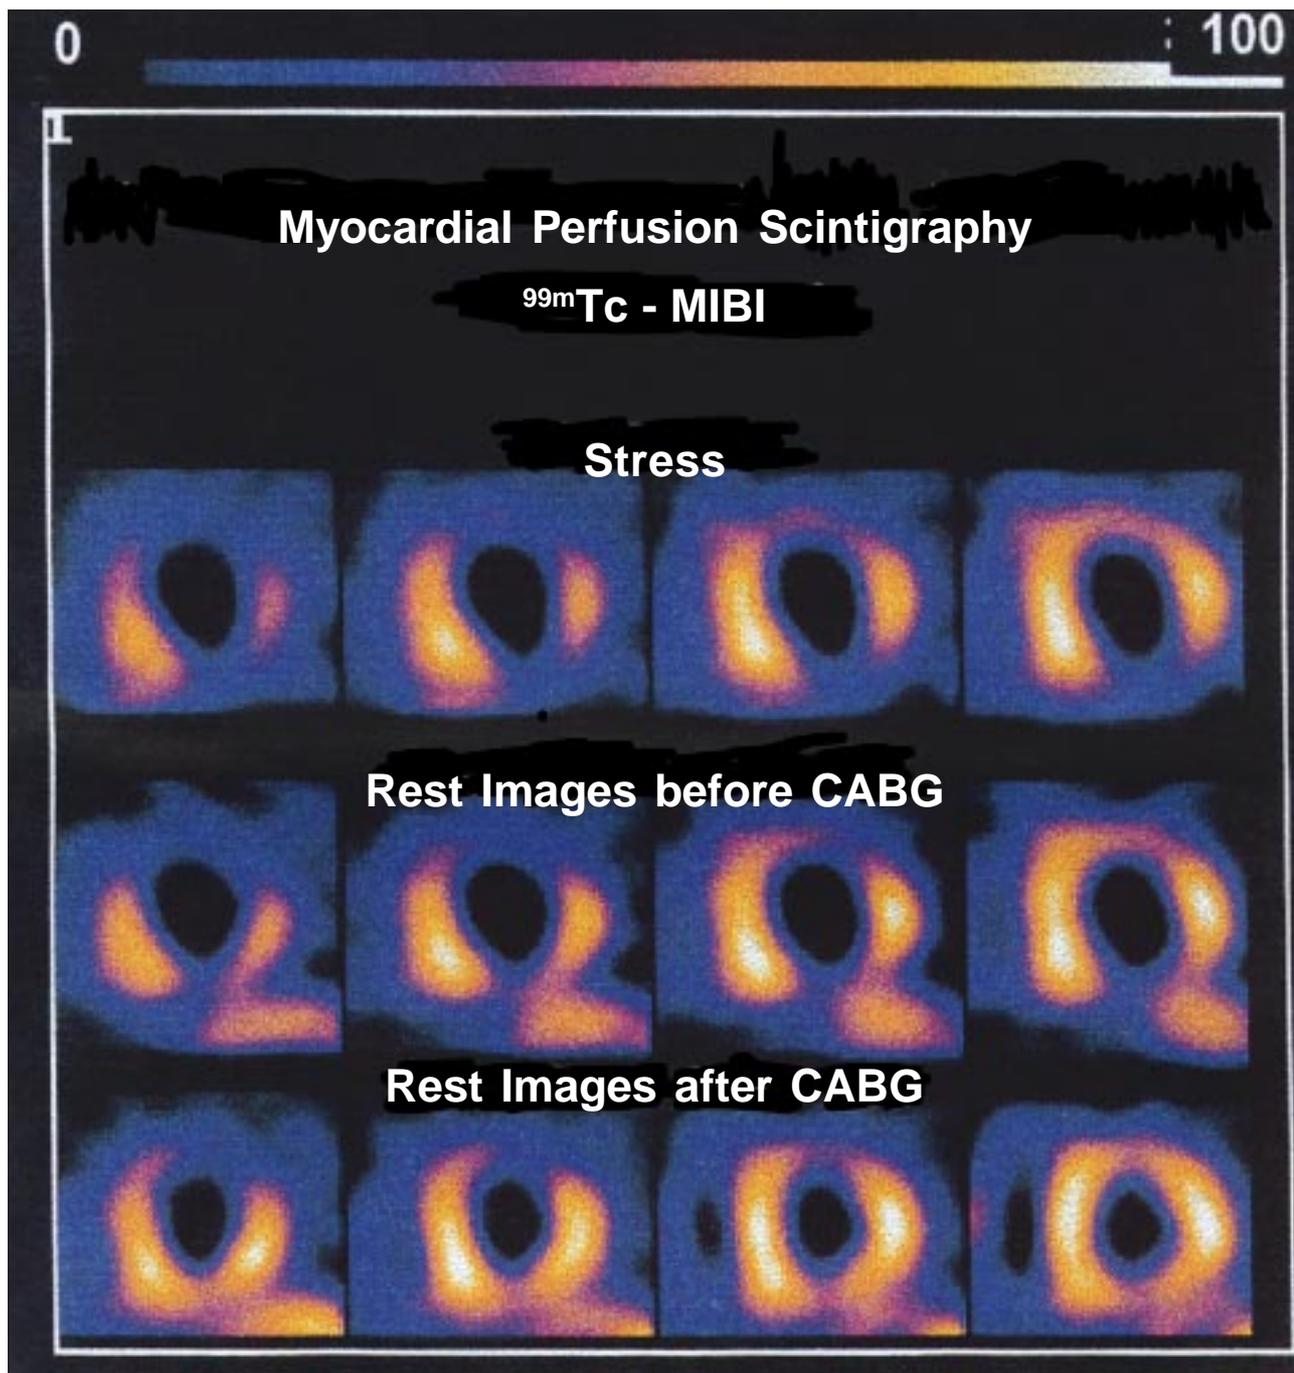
Myocardial perfusion scintigraphy with ^{99m}Tc-MIBI and tomographic slices in the oblique plan. Conventional protocol imaging shows persistent defects in the anterior, inferior and lateral regions. After CABG, images confirmed that these persistent defects contained viable muscle. CABG - Coronary artery bypass graft.
